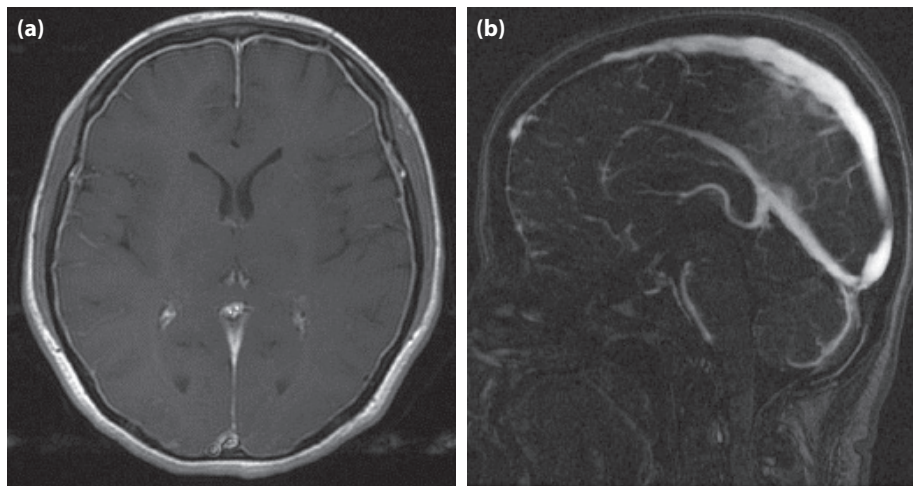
(a) Axial T1-weighted MR image following the intravenous injection of gadolinium shows widespread increase of pachymeningeal enhancement. (b) In the contrast-enhanced sagittal MR venography source image shows engorgement of dural sinuses.
